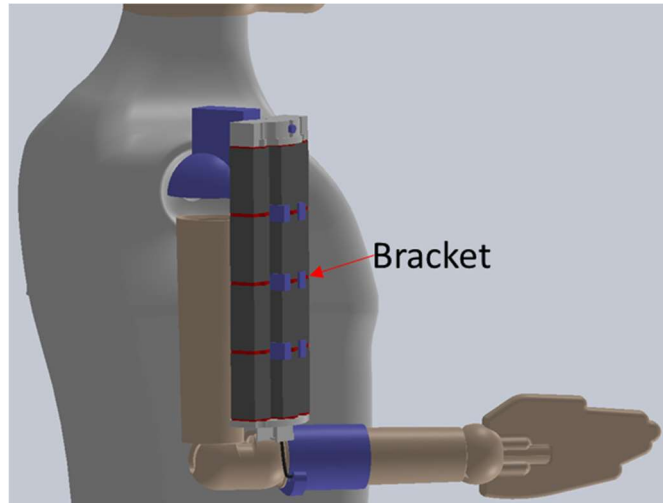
The CAD model of a potential exoskeleton, powered by the 3×4 artificial muscle. Three brackets are located on the CT-SDEAs' endplates of the middle artificial myofibril.
